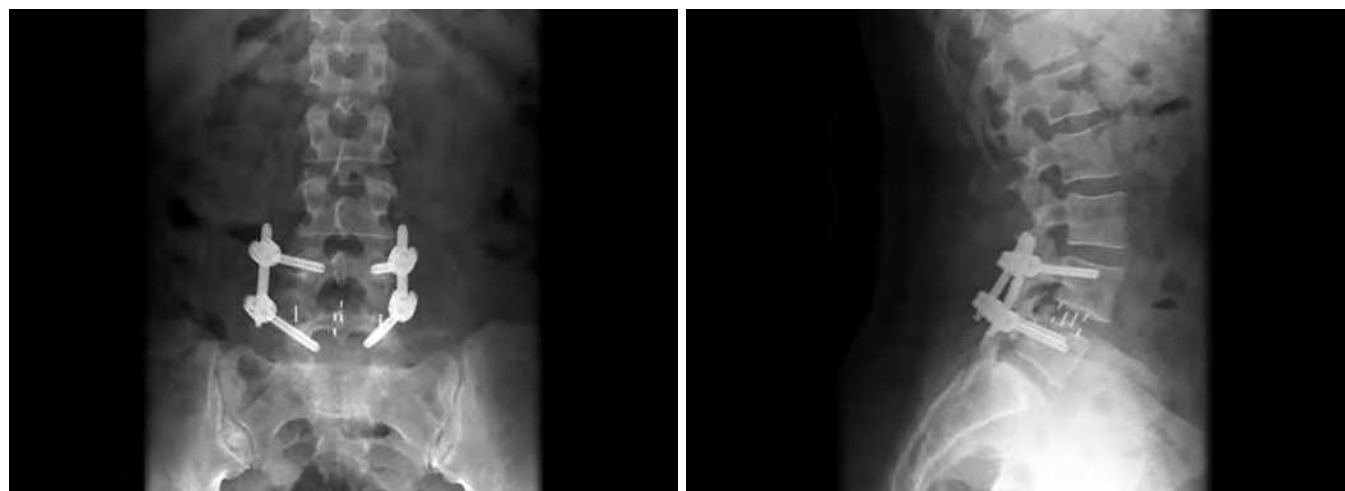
Anteroposterior and lateral X-ray following direct lateral interbody fusion and percutaneous pedicle screw fixation.
